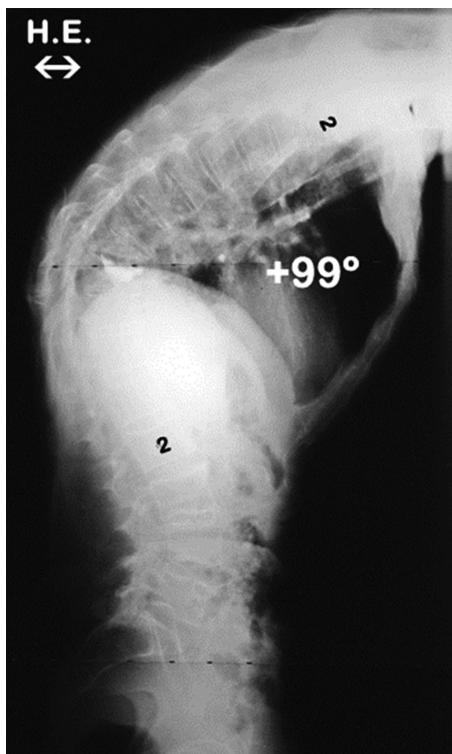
Supine lateral radiograph showing improvement of kyphosis to 99°.
